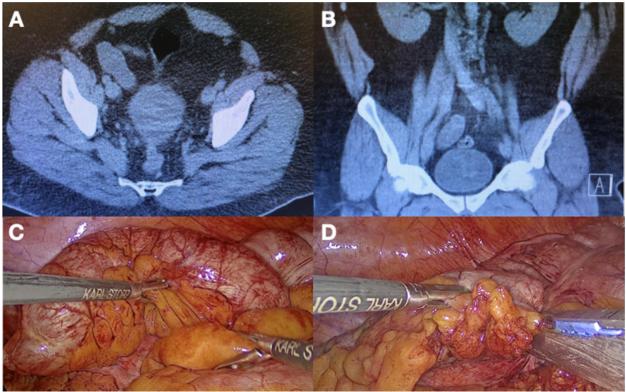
A) Simple abdominal CT scan, coronal cuts showing a dilated cecal appendix with semi-liquid content. B) Simple abdominal CT scan, axial cuts showing appendix dilation up to 28 mm. C) Laparoscopic approach showing a dilated appendix without evidence of perforation or mucinous implants. D) Laparoscopic appendectomy with a stapler at the appendiceal base.
